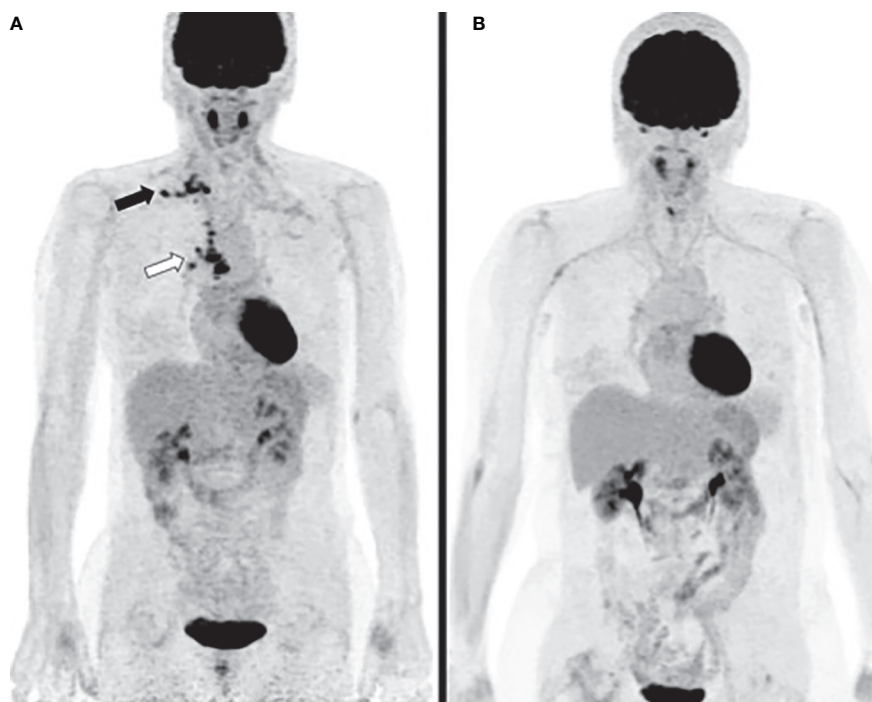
Case 1 (A) PET computed tomography (CT) at diagnosis reveals hypermetabolic activities of right hilar, mediastinal (white arrow) and supra-clavicular lymph nodes (black arrow). (B) PET CT three years after diagnosis shows complete metabolic response.
